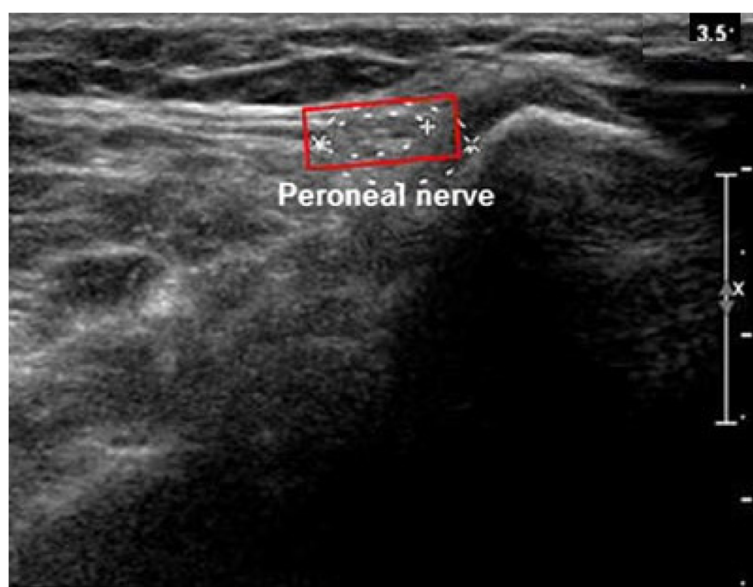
Ultrasonographic findings of patients with common peroneal mononeuropathy at the fibular neck
